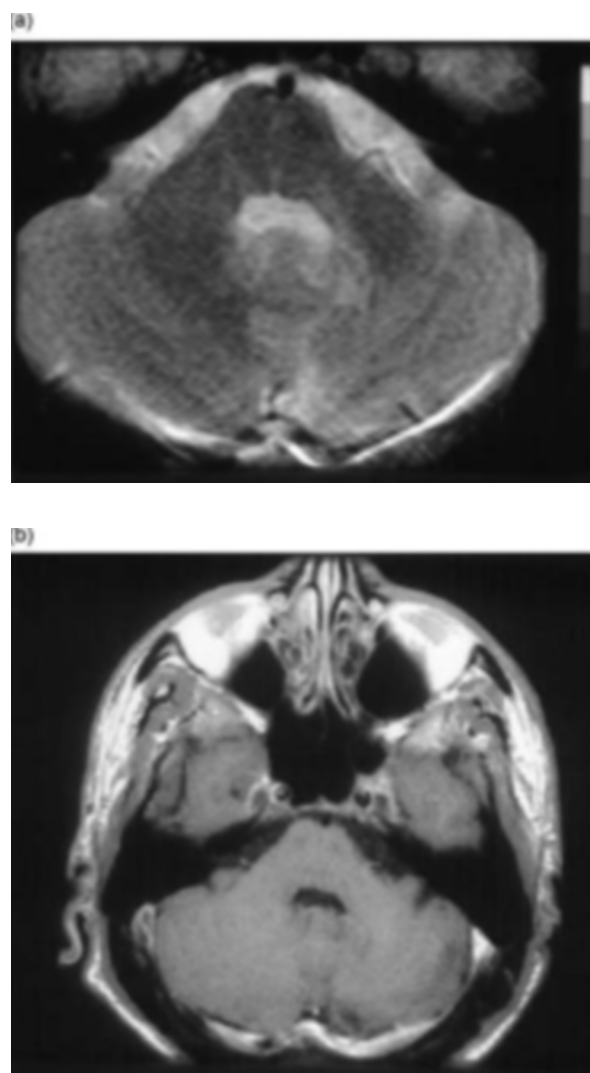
(a) Three months later, T2-weighted images show a hyperintense signal in the pathologic dentate area, without mass effect (enlarged and well shaped IV ventricle). (b) After gadolinium administration, there was no contrast medium in the same areas.
